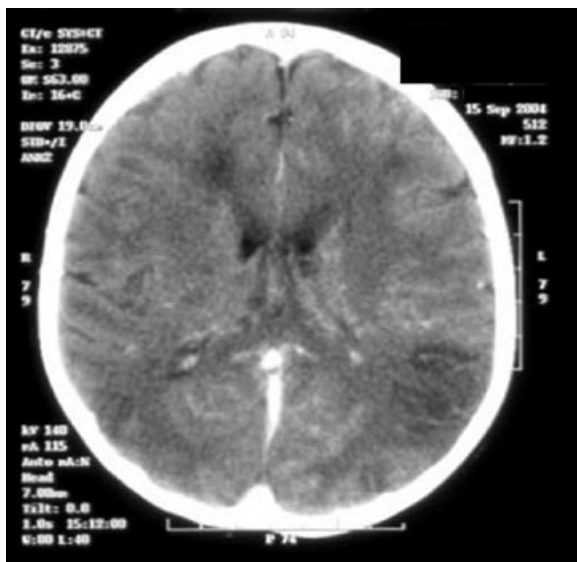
Girl aged 7: Head CT: ischemic lesions in parietal and occipital regions, edge enhancement after i.v. contrast administration.
